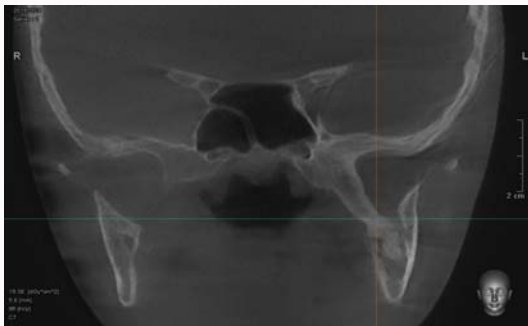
Coronal view of CT showing ossification of left sphenomandibular ligament.
